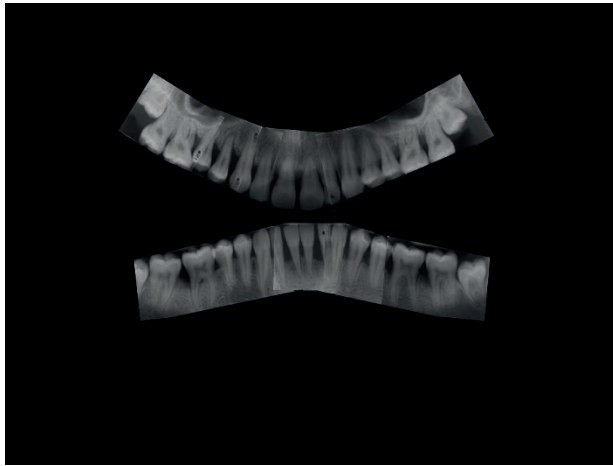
Patient 1 – Periapical intraoral radiographs
